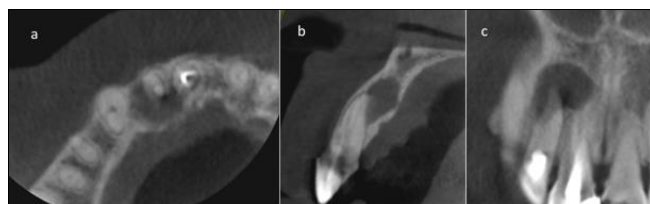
CBCT images of maxillary right lateral used to diagnose the presence of root canal, the size and location of the periapical lesion. A. Coronal reconstruction. B. Axial reconstruction. C. Sagittal reconstruction
